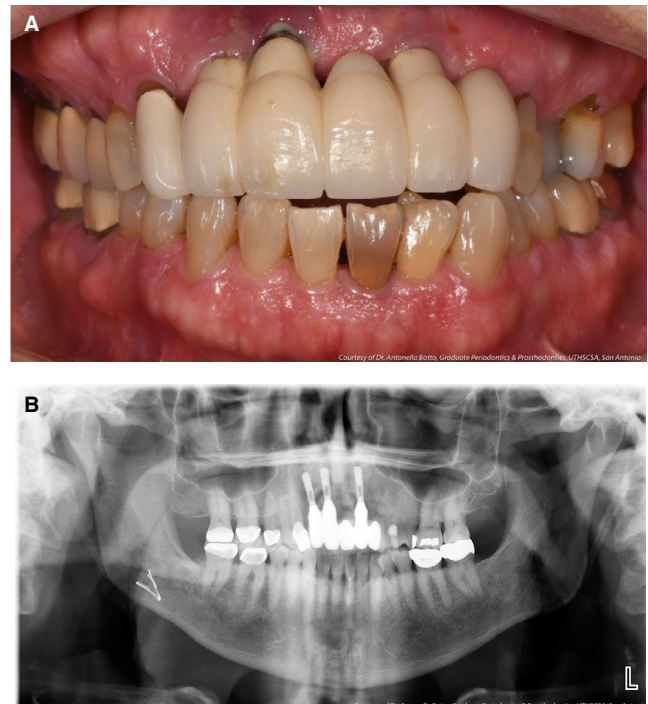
Clinical image showing suppuration of implant #8 associated with 5–8 mm probing depths. A, The excessive apical positioning of these tissue-level implants can be appreciated by the distance between the restorative margin and the desired cemento–enamel junction location as designed on the prosthesis; B, the panoramic radiograph depicts a large apicocoronal discrepancy between the cemento–enamel junction of adjacent teeth and the implant platforms that contributes to this complication
